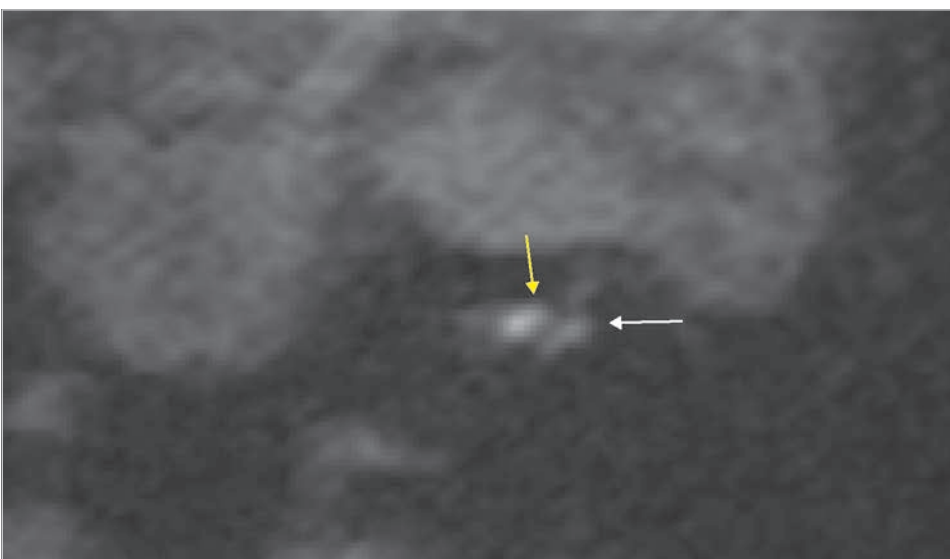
The coronal section of diffusion-weighted MRI demonstrated high signal intensity corresponding to presence of residual cholesteatoma. High signals seem to be located in the fundus of the internal auditory canal (yellow arrow), and the other signal in the inner ear located laterally to the internal auditory canal (white arrow).
